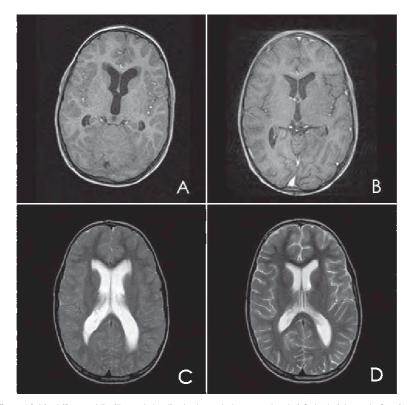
Subject (8 year old) with an obstructive hydrocephalus secondary to infratentorial mass before (A: T1weighted image; C: T2-weighted image) and after placement of a ventricoperitoneal shunt (B: T1-weighted image; D: T2-weighted image). Notice the location and lining of the areas with increased signal intensityhypointensities on T1weighted images in the periventricular white matter before drainage (A), disappearing after drainage (B).
